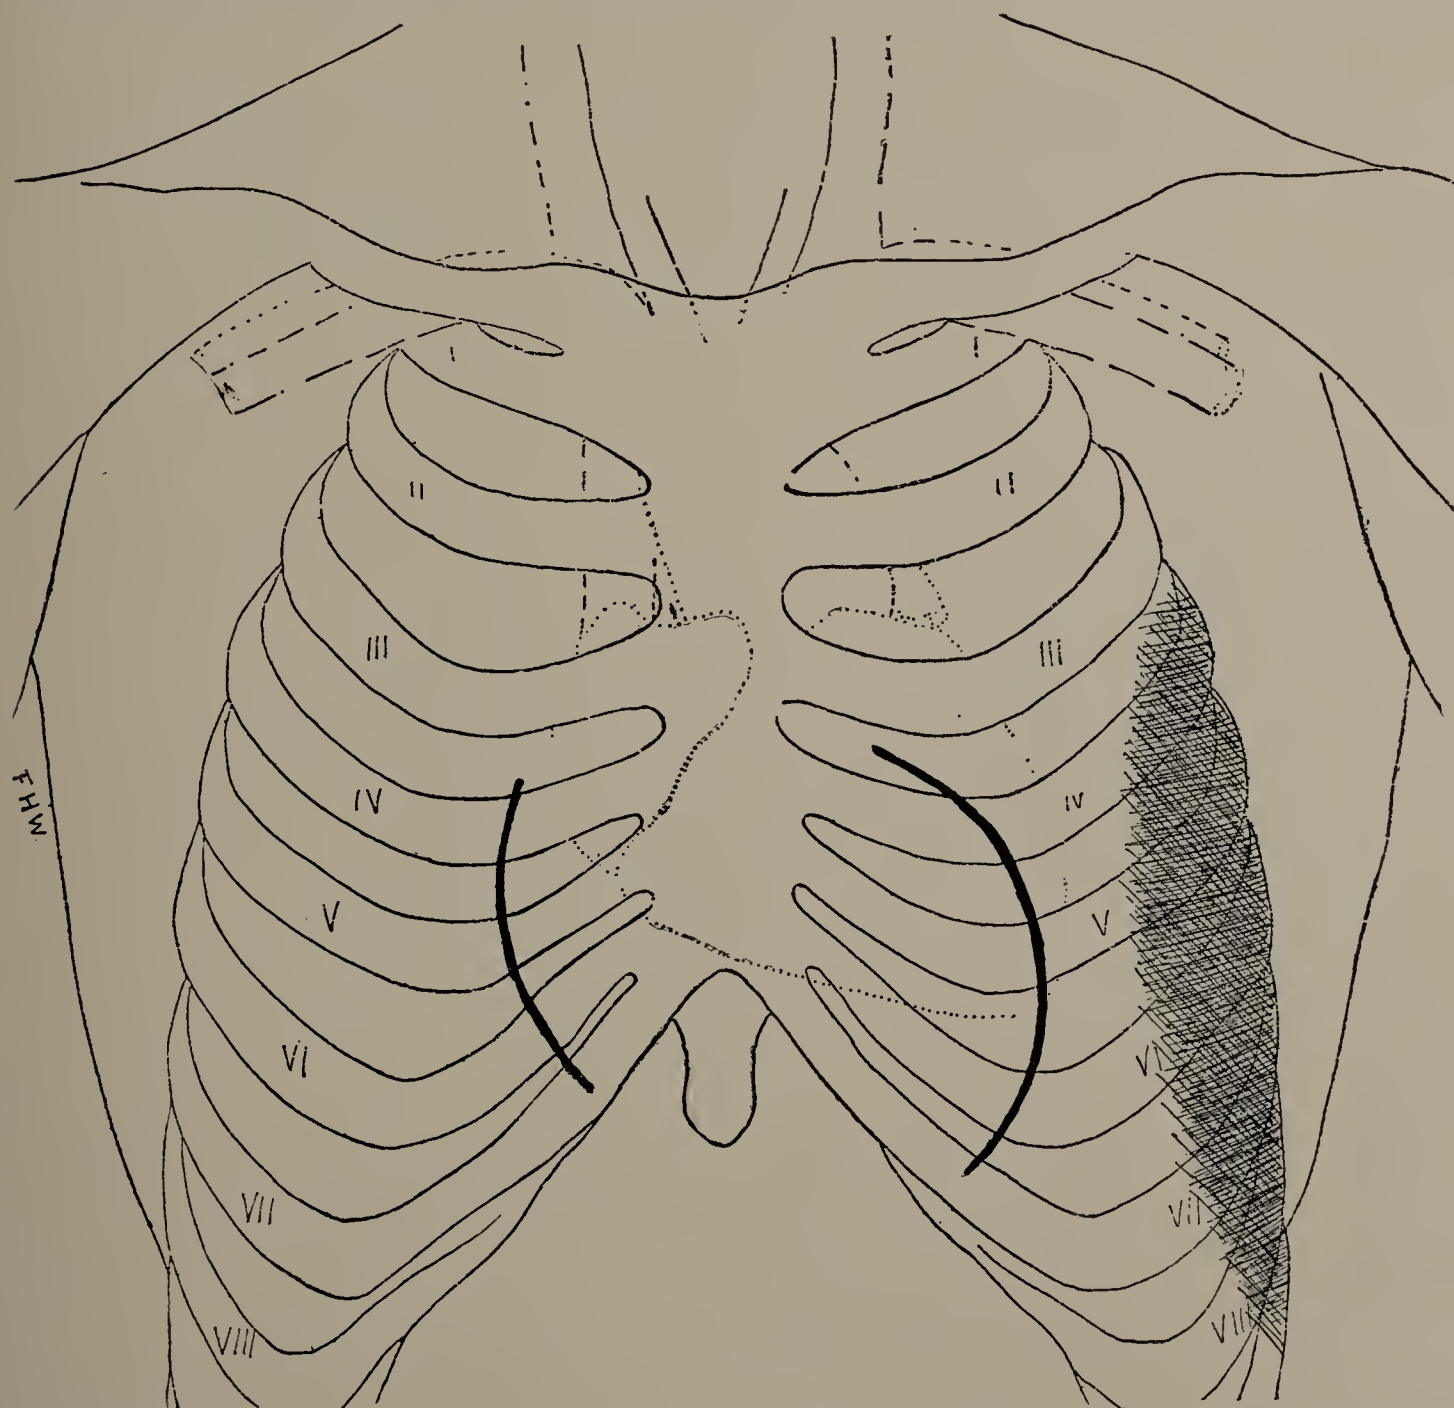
William T. March 17, 1897. X-ray examination with screen. Encysted pleurisy. Darkened area from third to ninth rib. Diaphragm lines not shown. Excursion 4.5 centimetres on right side; 2.5 on left side. (Cut one-third life size.)
